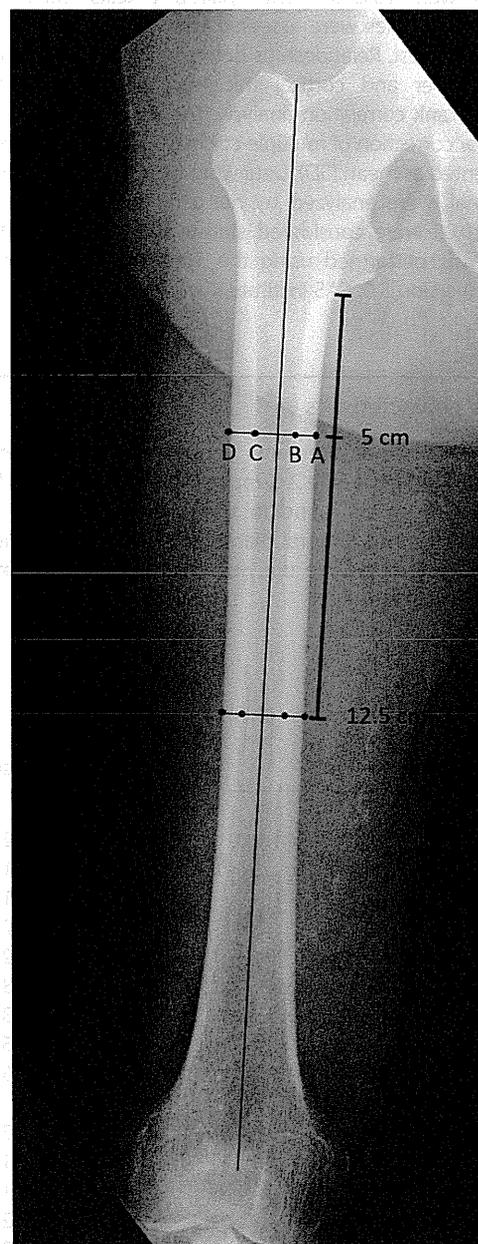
Points at which cortical thickness was measured on anteroposterior radiographs of the femurs.
